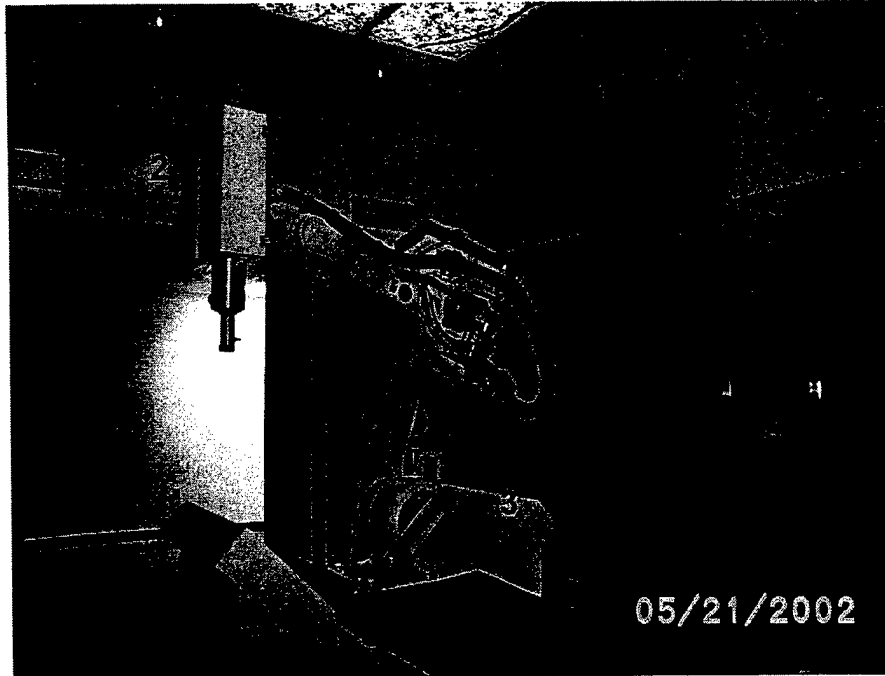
CyberKnife treatment facility at Georgetown (1. Ceiling mounted diagnostic X-ray sources, 2. Compact linear accelerator mounted on computer controlled robotic arm, 3. Amorphous silicon image detectors)
